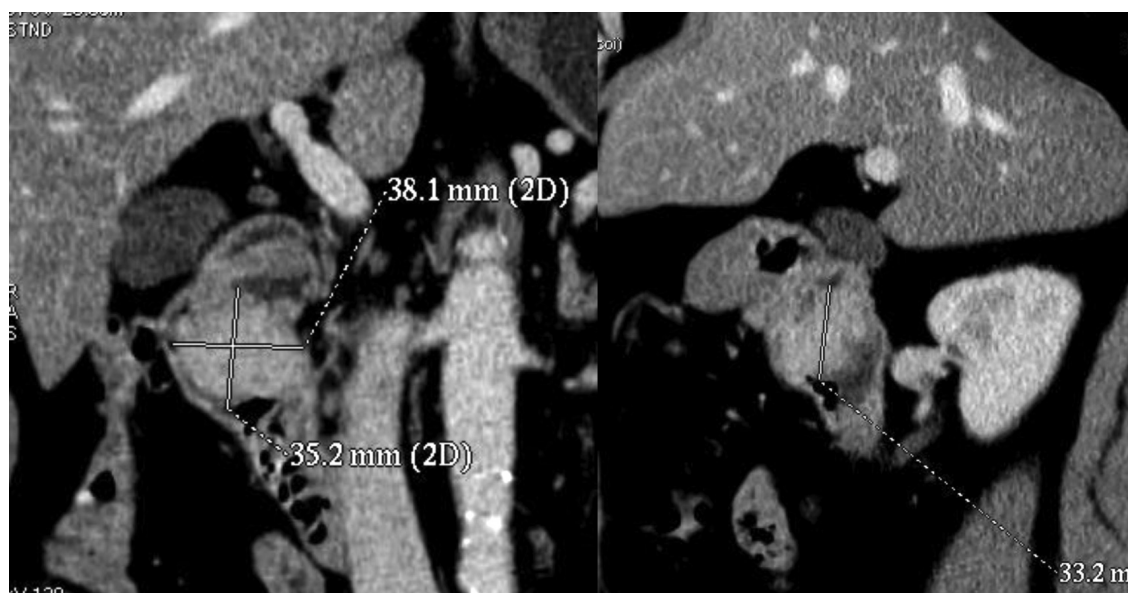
CT reconstructed pictures in coronal and sagittal planes: hypervascularized tumor of the duodenal bulb 38 by 35 by 33 mm in diameter, obstructing almost all lumen
